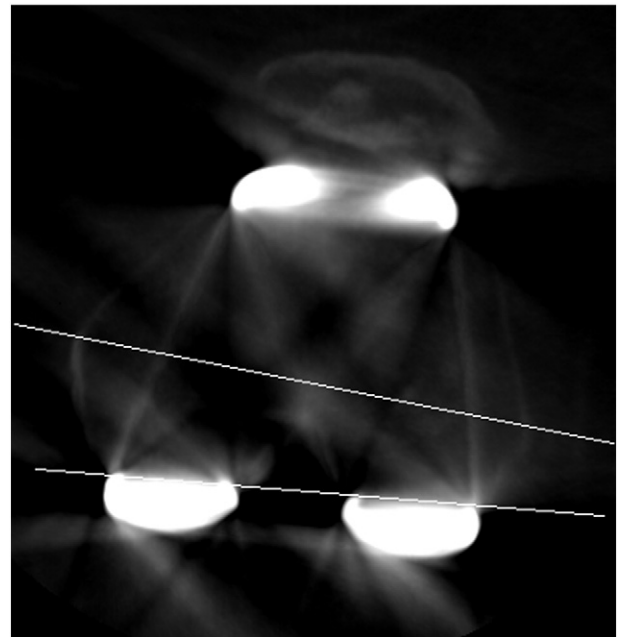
Axial CT image of an example femur displaying the lines representing the transepicondylar axis and the femoral implant orientation.
